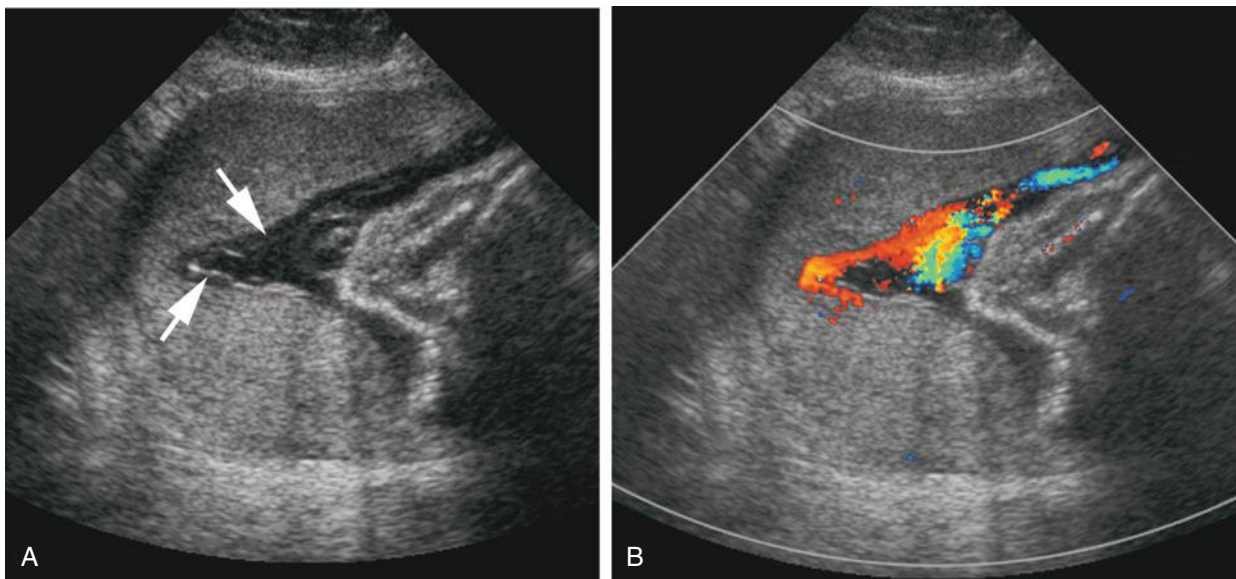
Pseudochoorioamniotic separation. A, Apparent chorioamniotic separation is seen with an unapposed amniotic membrane (*arrows*). B, Color Doppler imaging reveals that the structure thought to represent membrane was, in fact, umbilical cord.
